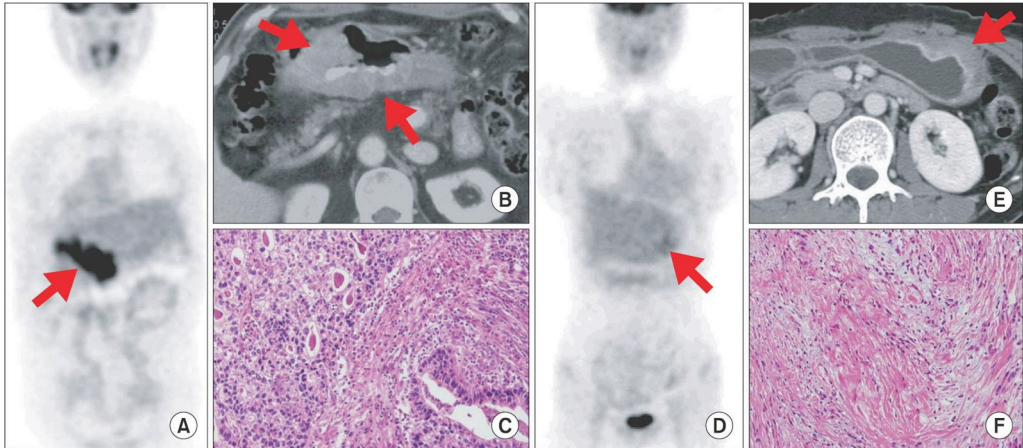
Fluorodeoxyglucose (^{18}F -FDG) uptake in advanced gastric cancers (AGCs). [17]
